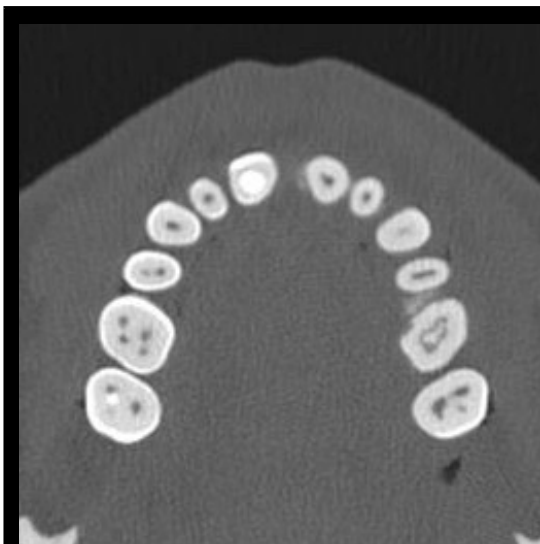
Axial CT Maxilla
